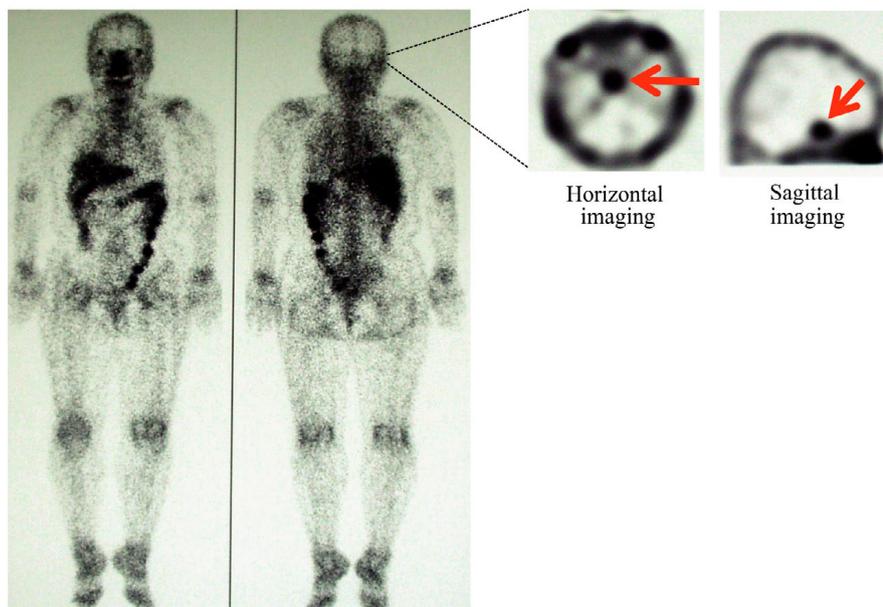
Ga scintigraphy. Increased uptake was observed in the pituitary gland (arrows).
